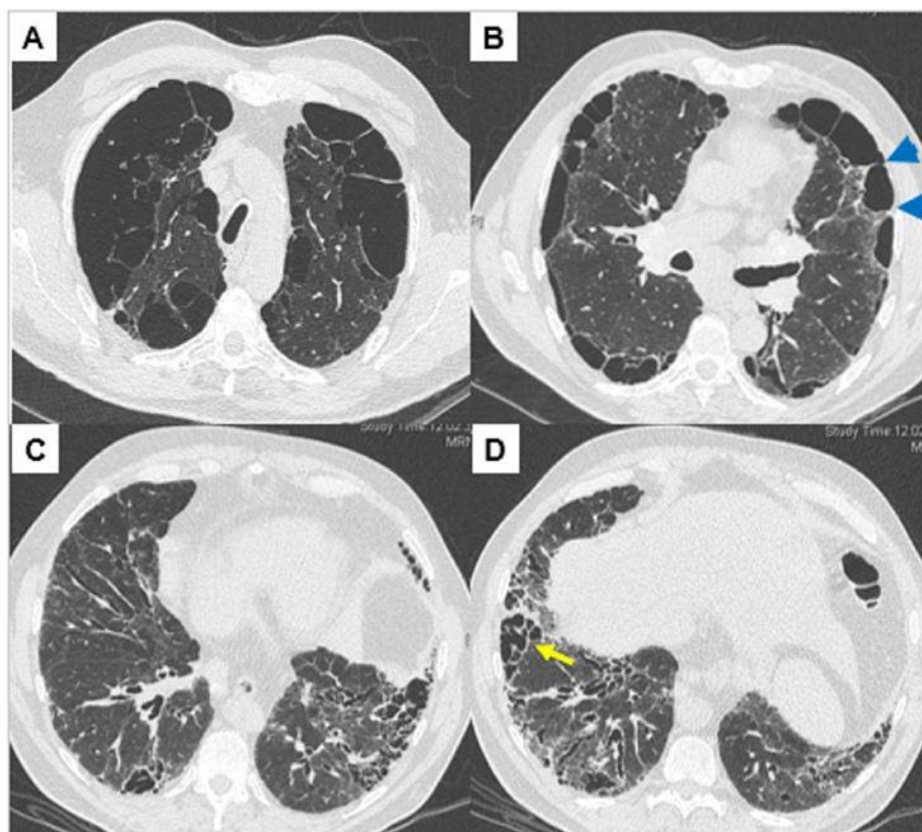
Parenchymal window of the chest CT scan in a patient with combined pulmonary fibrosis and emphysema syndrome. A: paraseptal emphysema. B: paraseptal emphysema with thickening of the interlobular septa (arrowheads). C, D: probable usual interstitial pneumonia pattern associated with subpleural cysts with thickened walls suggesting the coexistence of emphysema and fibrosis in the same areas (arrow).
